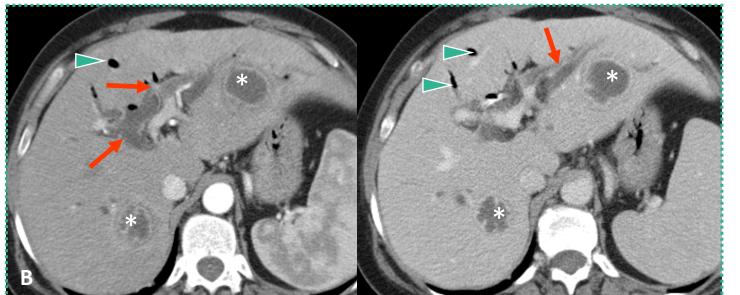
Contrast-enhanced CT - Acute bacterial cholangitis (two different cases A and B).
